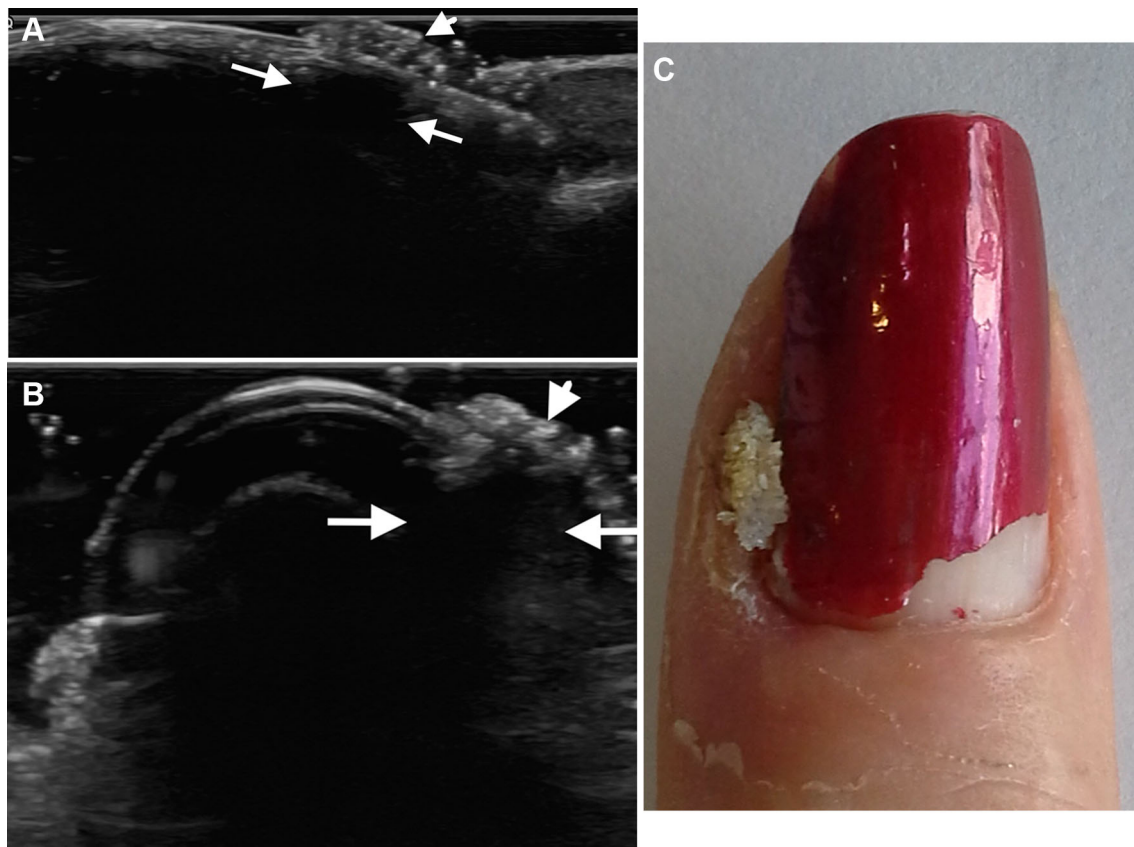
Subungual warts. Ultrasound a longitudinal and b transverse views. Hypoechoic fusiform eccentric lesion (*arrows*), also hypovascular, with an exophytic hyperechoic component located in the lateral
